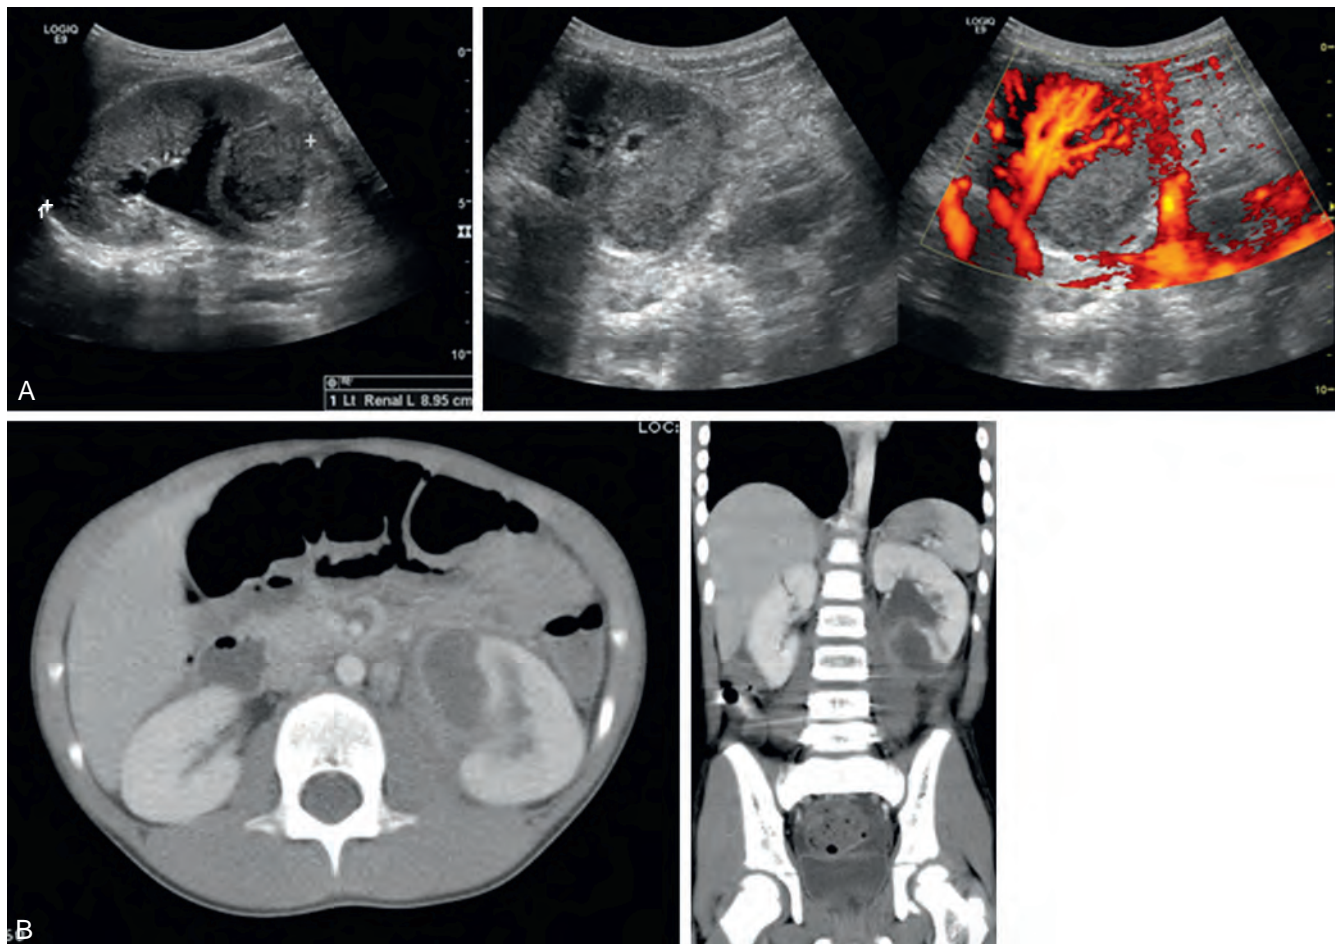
A 6-year-old boy presented with abdominal pain, elevated erythrocyte sedimentation rate and C-reactive protein, and inability to stand erect. A, Sonogram of the kidneys with Doppler views demonstrates a heterogeneous collection in the lower pole of the left kidney. B, On computed tomography scan, this region is confirmed as a renal abscess.
